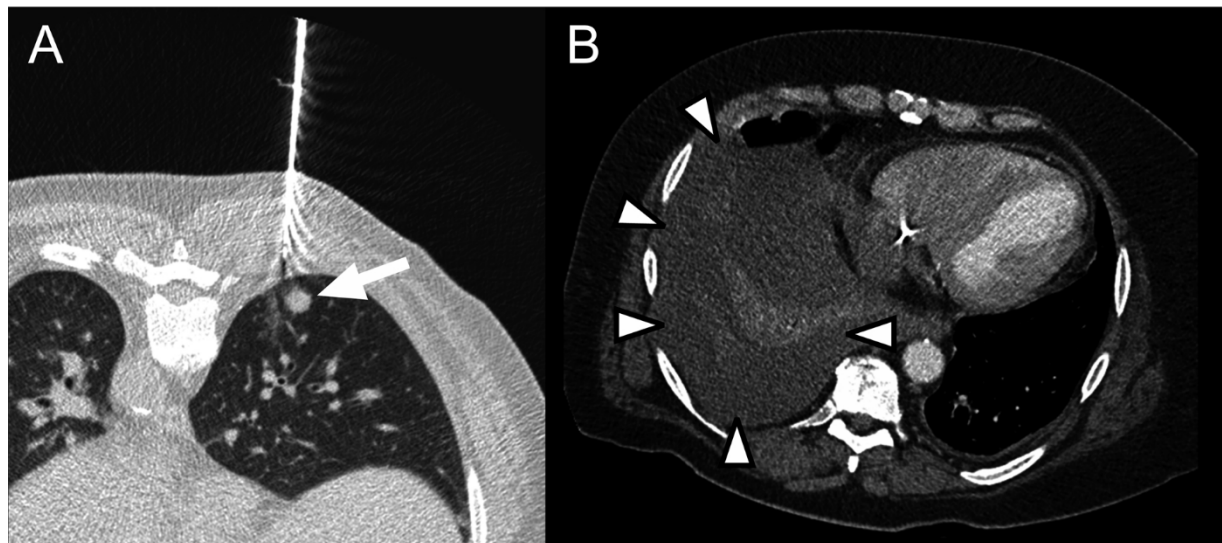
A 52-year-old man with a history of renal cell cancer underwent CT-guided biopsy of a pulmonary nodule in the right lower lobe (A, arrow) because of the suspicion of metastatic disease. The biopsy procedure was initially thought to be uneventful, but a hemothorax developed that became infected (B, arrowheads). The patient eventually underwent video-assisted thoracoscopic surgery to treat the infected hemothorax and was hospitalized for 16 days.
